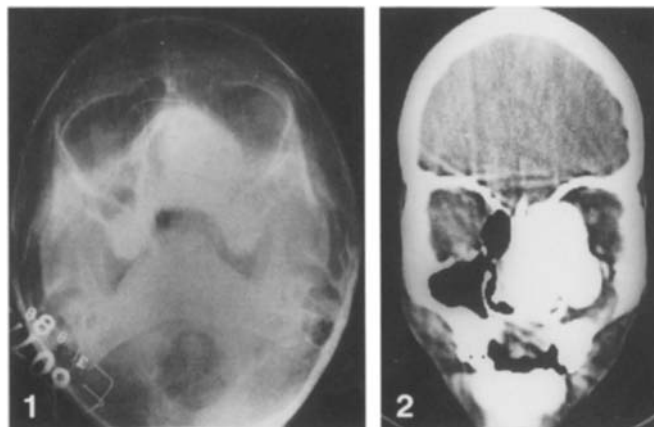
Plain X-ray showing bony mass filling the nasal cavity and ethmoidal and maxillary sinuses on the left side
